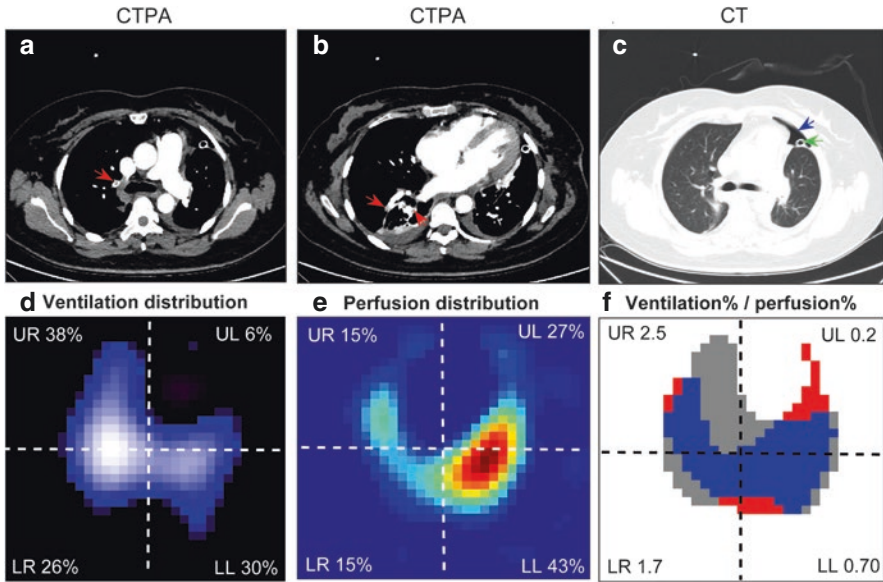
Computed tomography (CT), CT pulmonary angiography (CTPA), and electrical impedance tomography (EIT) results showing ventilation and perfusion defects in a 47-year old supine woman 1 day after thoracic surgery. CTPA demonstrated multiple emboli in the right pulmonary artery branches (*red arrows in panels a and b*). Small pneumothorax in the left ventral region was detected in the CT scan (*blue arrow in panel c*). The position of the drainage tube in the thoracic cavity is indicated (*green arrow*). Functional EIT image of ventilation distribution (d) shows the low-ventilated regions in dark blue and the high-ventilated regions in white. The values in the image corners give the percentage of ventilation in the corresponding quadrant. Functional EIT image of perfusion distribution shows the regions with high perfusion marked in red and low perfusion in blue (e). The values give the percentage of perfusion in the corresponding quadrant. Functional EIT image showing the distribution of regional ventilation/perfusion ratios (f) uses the following annotation: regions with high ventilation and low perfusion are marked in gray (corresponding pixels show the ventilated but not perfused regions), low-ventilation and high-perfusion regions in red (corresponding pixels show the perfused but not ventilated regions), and good ventilation–perfusion matching in blue (pixels belong to both regions and exhibit both ventilation and perfusion). Regional ventilation%/perfusion% ratios shown in each quadrant correspond to ventilation distribution (in %) over perfusion distribution (in %) in the corresponding quadrant. *LL* lower left lung, *LR* lower right lung, *UL* upper left lung, *UR* upper right lung. (Reprinted from [3] with permission of the American Thoracic Society. Copyright © 2021 American Thoracic Society. All rights reserved)
